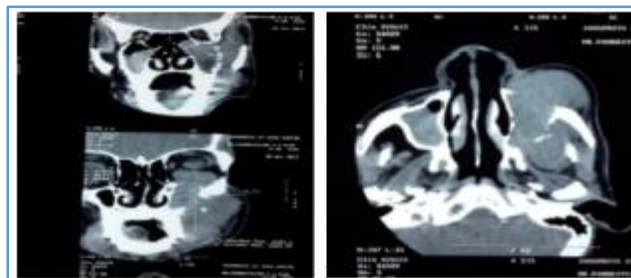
CT Scan of the paranasal sinuses: Soft tissue density in the left maxillary sinus
